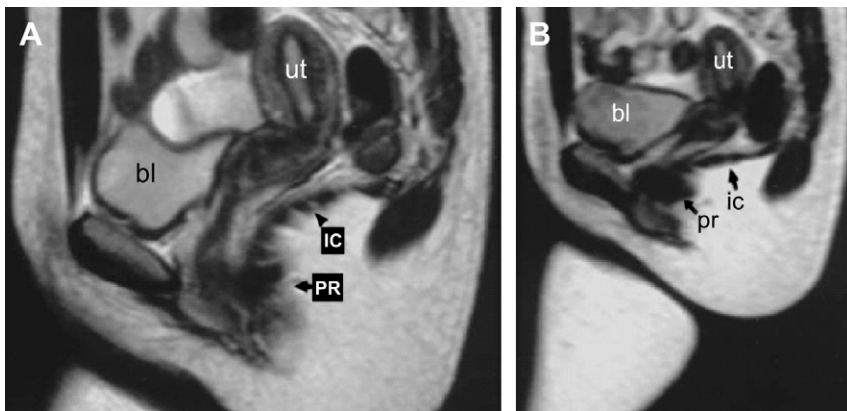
MRIs at rest and squeeze in the mid sagittal plane. These images show movements of the anorectal angle and levator plate (formed by the ileococcygeus muscle). Sagittal at rest (A) and straining (B) showing the changes in the different components of the levator ani. On straining, the resting convex shape of the IC becomes flattened, and the genital hiatus reduces in size because of ventral movement of the puborectalis. bl, bladder; ut, uterus; IC, ileococcygeus; PR, puborectalis. (Adapted from Singh K, Jakab M, Reid WM, et al. Three-dimensional magnetic resonance imaging assessment of levator ani morphologic features in different grades of prolapse. *Am J Obstet Gynecol* 2003;188:910–5; with permission.)
